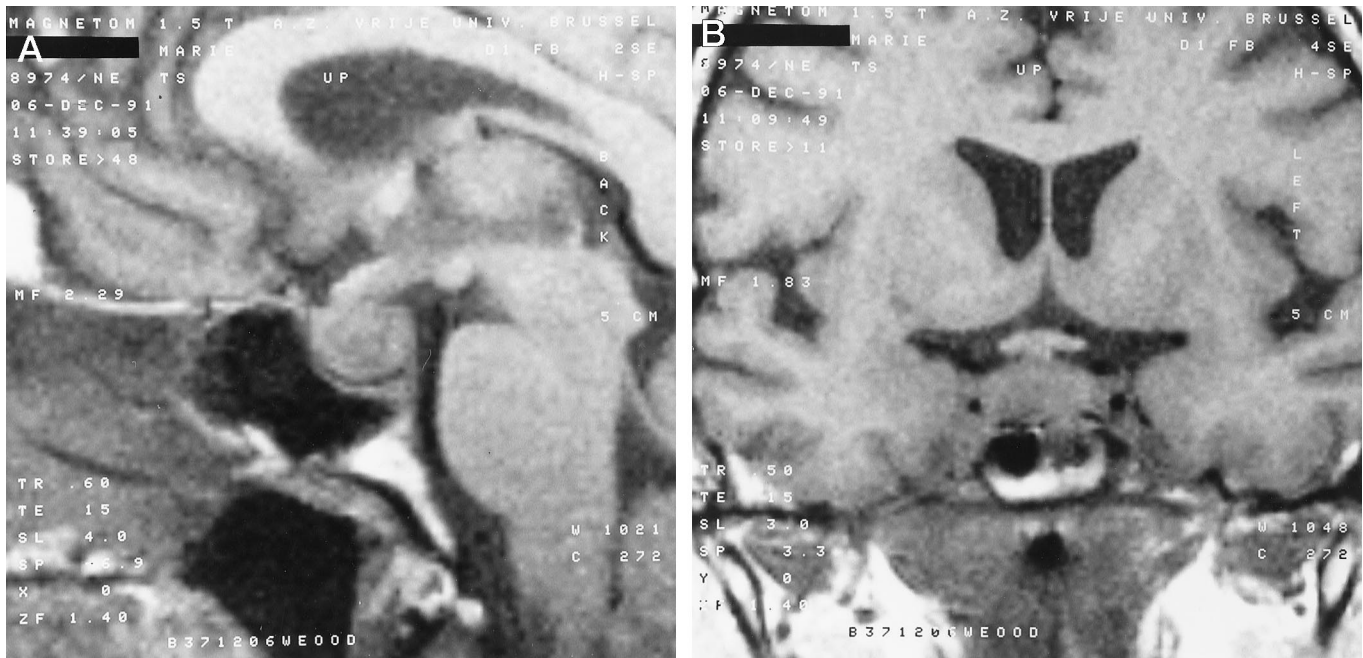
A and B: Pituitary magnetic resonance imaging at time of admission, showing an intrasellar mass and a thickening of the pituitary stalk.
